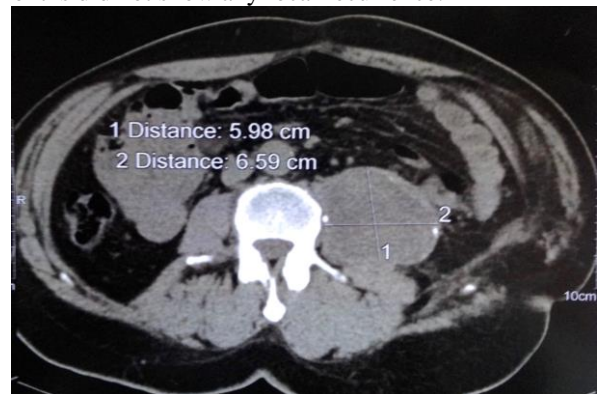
Cross-sectional CT scan without contrast injection, showing a cystic mass developed at the expense of the left psoas muscle.
